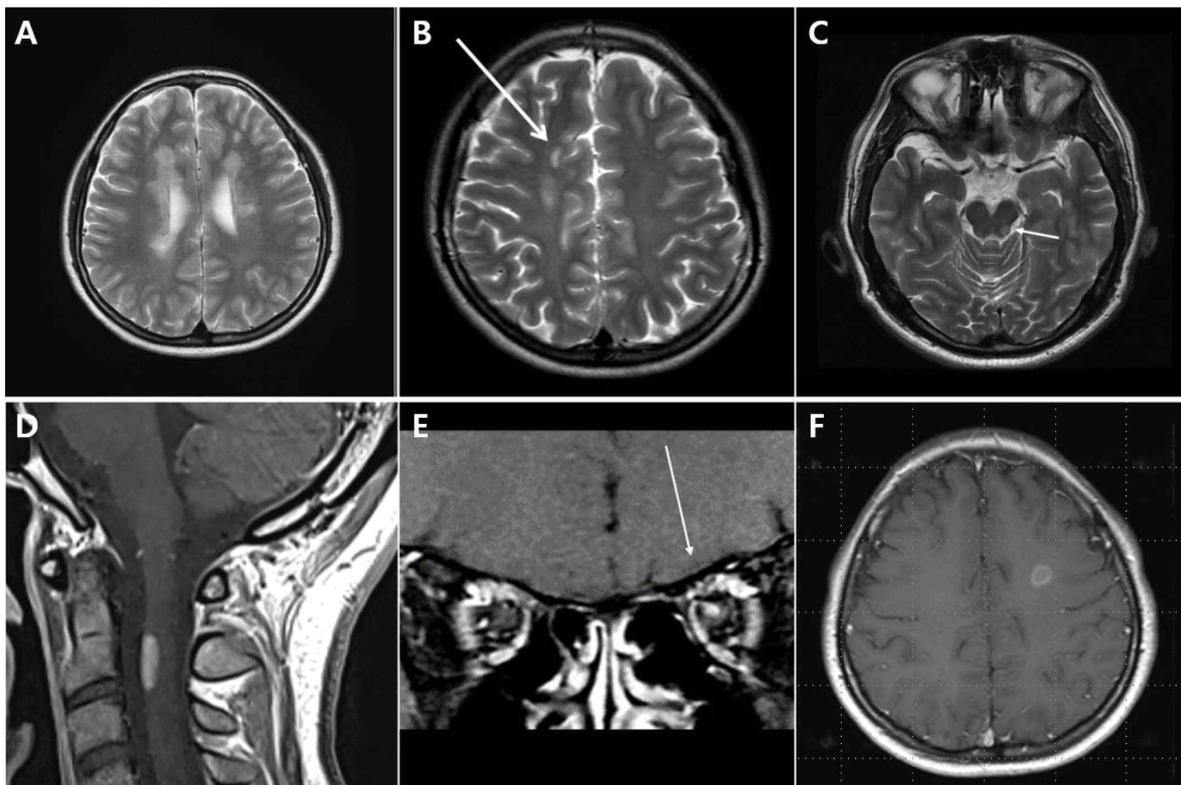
Example of lesion for multiple sclerosis MRI Criteria of dissemination in space (A) periventricular lesions; (B) juxtacortical lesions; (C) infratentorial lesions; (D) spinal cord lesion; (E) optic nerve lesion. Gadolinium-enhancing lesion in T1 gadolinium weighted image; (F) are visible in the patient with MS.
